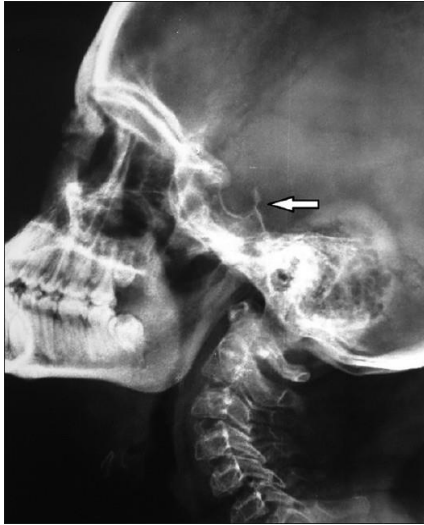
X-ray skull: enlarged sella, hypoplastic maxillary and frontal sinuses
